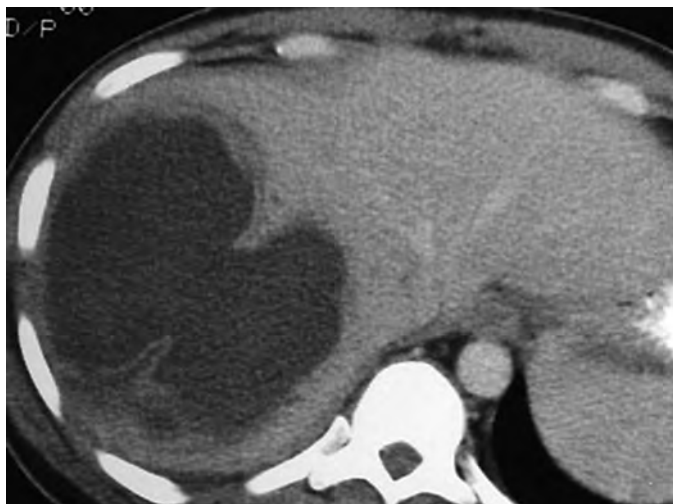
Amebic abscess: CT features. A large unilocular mass with an enhancing wall demonstrates a thin peripheral hypodense rim of surrounding edema that is typical of amebic abscesses.
